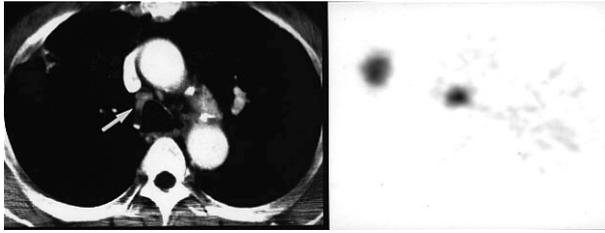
Inflammatory nodule. CT image shows nodule in left lung, mimicking lung cancer. FDG PET shows intense accumulation in the nodule. The nodule disappeared 3 months later.
